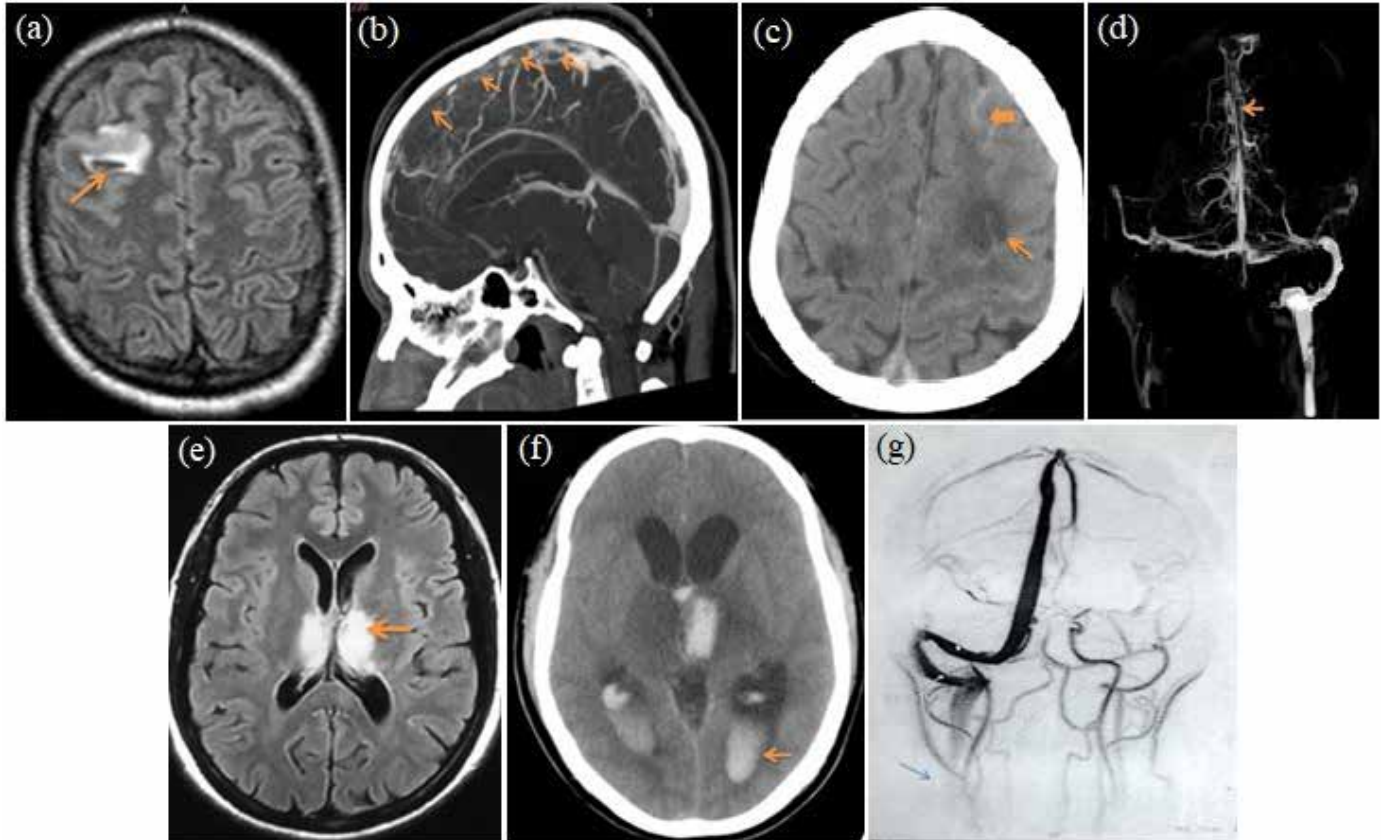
27 Year old male presented with complaints of headache, seizure and loss of consciousness had (a) FLAIR sequence of brain MRI showing hyperintensity (arrow) in right parietal region with hemorrhagic transformation and (b) CT venography showing superior sagittal sinus and left transverse sinus thrombosis (arrow). A 33 Year male patient presented with headache left upper limb weakness and seizure had (c) plain CT Head showing multifocal edematous hypodense area (thin arrow) in bilateral fronto-parietal lobes and left side subarachnoid hemorrhage (thick arrow) and (d) CT venography showing entire course of superior sagittal sinus (arrow), bilateral transverse sinus and sigmoid sinuses thrombosis. 39 year male, presented with fever, headache, confusion and alteration in sensorium had (e) MRI FLAIR sequence showing bilateral thalamic infarcts (arrow), (f) plain CT brain showing intraventricular hemorrhage (arrow) in bilateral lateral ventricles up to fourth ventricles and (g) MRI venography showing extensive venous sinus thrombosis including deep venous system
